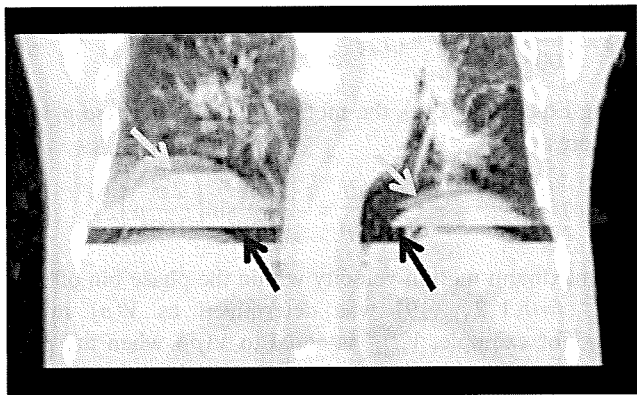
Examples of misalignment artifacts and motion-blurring artifacts. Upper arrows show misalignment artifacts resulting from mismatches in respiratory phase between adjacent couch positions. The diaphragm is imaged as two disconnected parts. Lower arrows show motion-blurring artifacts. The edges of the diaphragm become blurred due to poor temporal resolution of the CT scanner to the velocity of the diaphragm.
